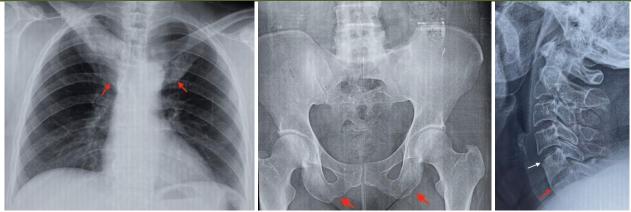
a) Frontal chest X-ray showing osteocondensation and hyperostosis of the sternal end of the bilateral first ribs and the right clavicle (arrows). b) X-ray of the pelvis showing irregularity of the cortical bone of the ischium in favour of enthesitis (arrows), fusion with disappearance of the interline of the right sacroiliac joint and condensation of the margins of the left sacroiliac joint in favour of sacroiliitis. c) Radiograph of the cervical spine in profile showing erosion of the anterior corner of C5 (white arrow) with C5-C6 syndesmophyte (red arrow).
